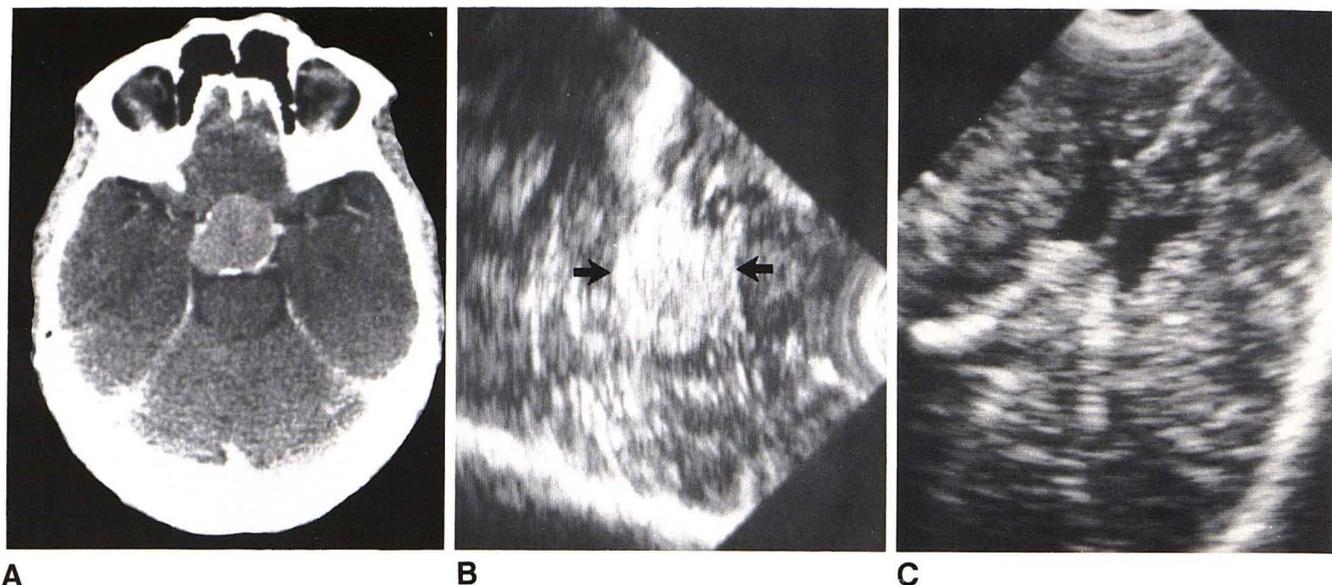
A, Contrast-enhanced CT scan shows suprasellar extension of pituitary adenoma. Intraoperative sonograms confirm solid nature of adenoma (B, arrows) and define normal ventricles (C). Postoperative sonography showed no change in ventricles.
